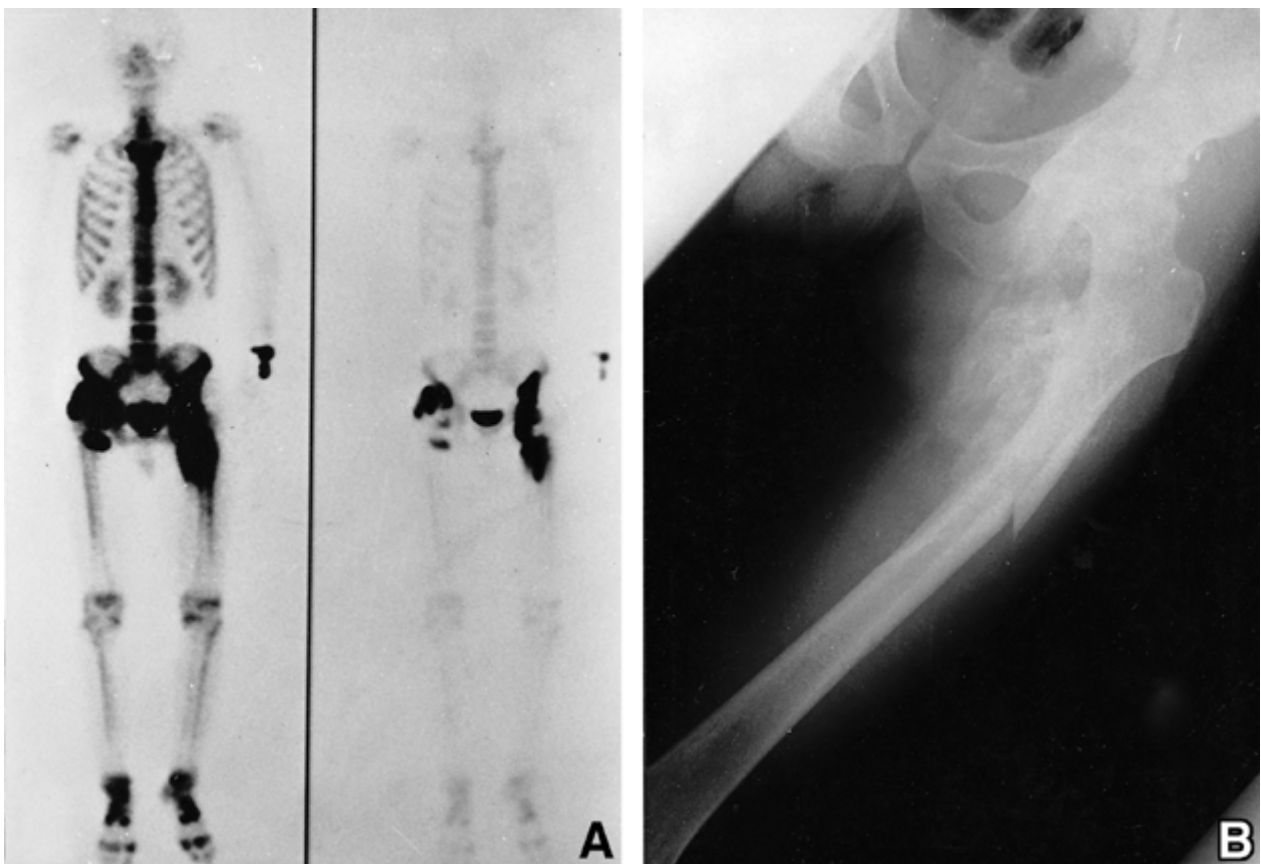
(A) Pre-fracture whole body bone scan finding of case 2 shows hot uptakes in both hip. (B) Simple radiographic finding of case 2 shows fracture occurred at the tip of heterotopic ossification of the left femur which shows relatively thick cortex.
